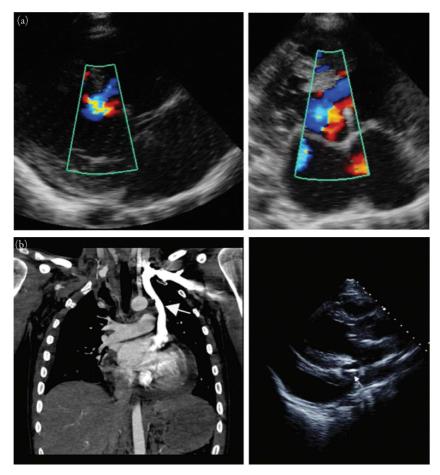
(a) Tetralogy of Fallot. Ventricular septal defect with color flow Doppler between the 2 ventricles on parasternal long axis (left) and apical 4-chamber (right) view. (b) Persistent left superior vena cava. Left panel: CT showing L-sided superior vena cava (large arrow). Right panel: Transthoracic echocardiogram showing catheter in the dilated coronary sinus (small arrow). Adapted from Figures 3 and 4 of Goyal S, Punnam SR, Verma G, Ruberg FL. Persistent left superior vena cava: a case report and review of literature. Cardiovasc Ultrasound. 2008;6:50.
